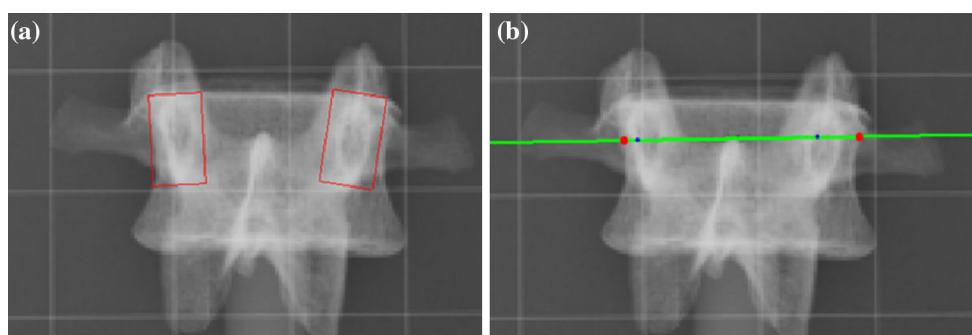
Axial vertebral rotation measurement on radiograph using Stokes' method. a Select the pedicle areas; b pick the intersection points by the line and the edge of vertebral body (red dots)
